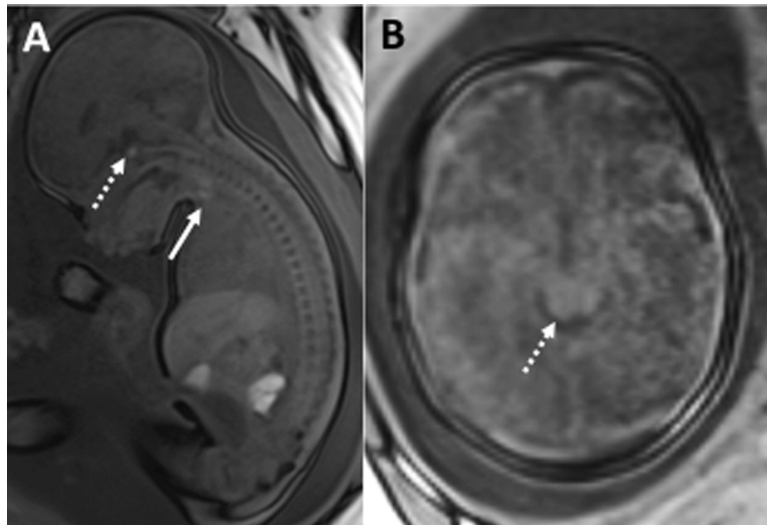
Normal T1-weighted images in a fetus of 34 week of gestation (A) Sagittal T1-weighted image shows the normal T1 hyperintense thyroid pituitary gland (*dashed arrow*) and thyroid gland (*arrow*). (B) Axial T1-weighted images in the same fetus show normal myelination with T1 shortening in the tegmentum of the pons (*dashed arrow*). Note the T1-contrast and lower SNR compared to SS-FSE sequence in fetus Figure 2 (G, H).
